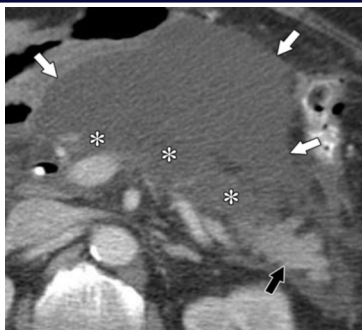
Subtypes of necrotizing pancreatitis on axial contrast-enhanced CT images. (a) Image of combined pancreatic and peripancreatic necrosis in a 58-year-old woman shows nonenhancement of the body (*), normal enhancement of the pancreatic tail (black arrow), and a large ANC in the lesser sac (white arrows).
